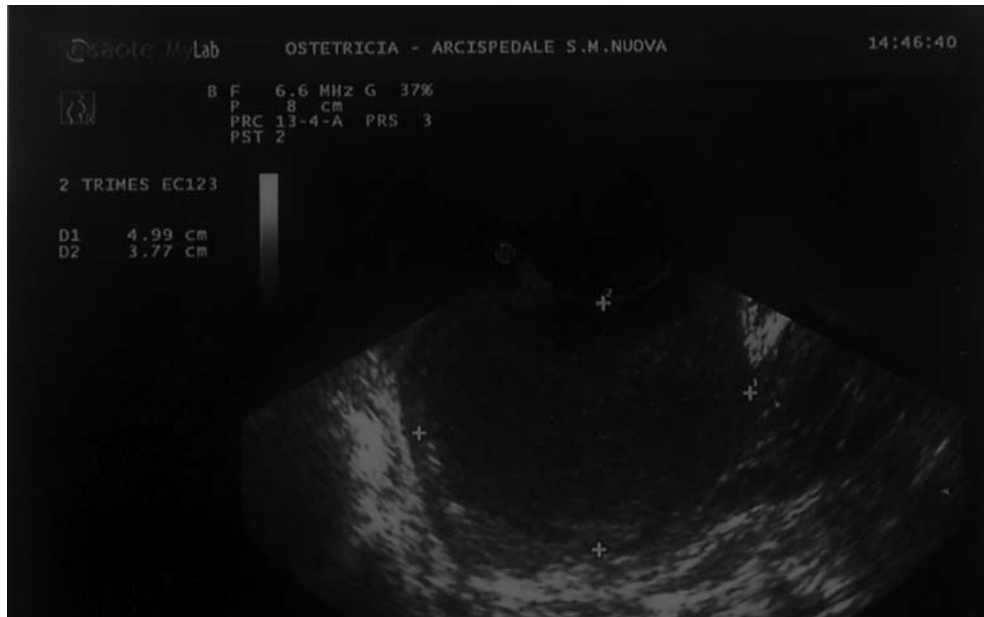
Ultrasound appearance of diffuse large B-cell extranodal lymphoma of the cervix misdiagnosed as a myoma.*
